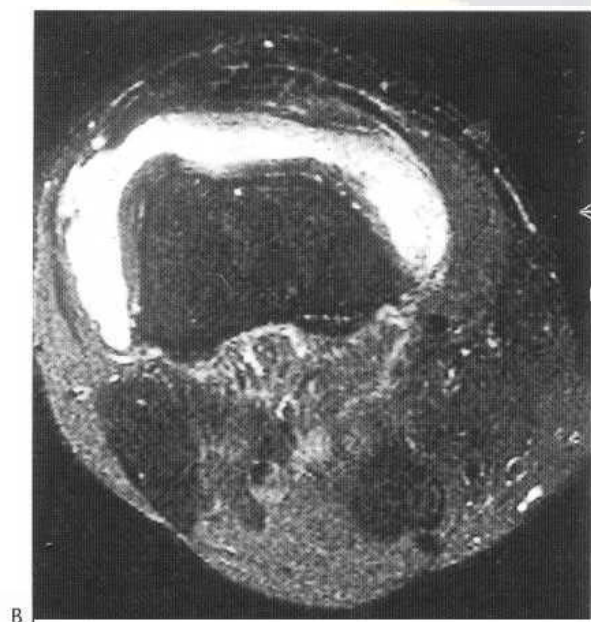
Lipoma arborescens of the knee joint. Axial T_1 -weighted (A) and T_2 -weighted (B) fat-suppressed MR images through the suprapatellar recess showing numerous fatty fronds of synovium and a large joint effusion. Note how the high signal intensity villous projections on the T_1 -weighted image are suppressed on the T_2 -weighted fat-suppressed sequence.
